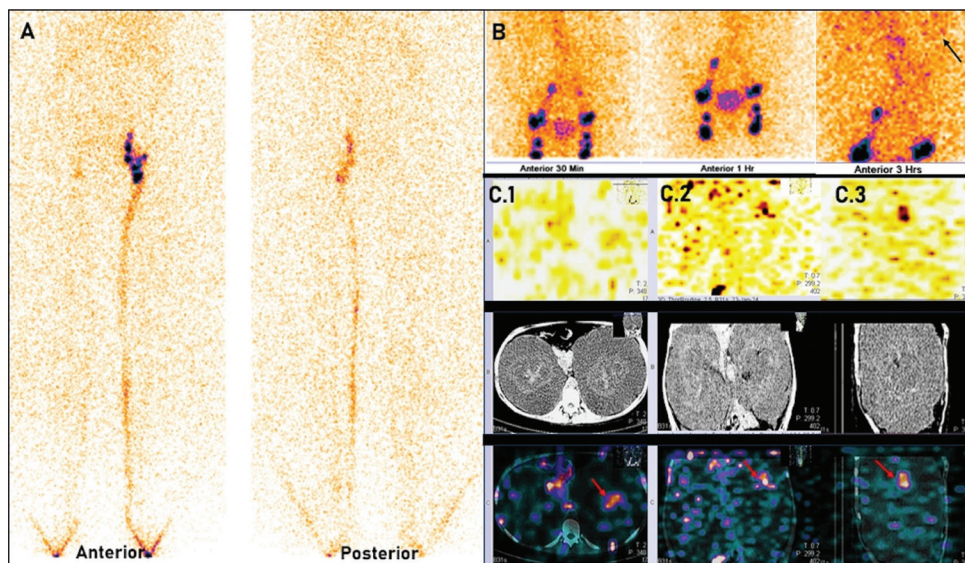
The Technetium-99m sulfur colloid was injected in the first web space of both lower limbs of the patient, and a whole-body sweep image followed by static images was acquired. (a) Normal transit of radiocolloid in the left lower limb into the inguinal nodes and faintly visualized lymphatics and inguinal nodes in the right lower limb – could be secondary to chronic deep venous thrombosis. The static images (b) till 3 h show normal visualization of inguinal and iliac nodes with visualization of the urinary bladder by 30 min and faint radiocolloid uptake in the left renal fossa in the 3-h image (black arrow). Single-photon emission computed tomography-computed tomography of the abdomen (axial – c.1, coronal – C.2, and sagittal – C.3) showed faint radiocolloid accumulation in the left renal pelvis. In addition, there was bilateral hypodense perinephric collection consistent with a history of renal lymphangiectasia with cystic changes in the kidney
